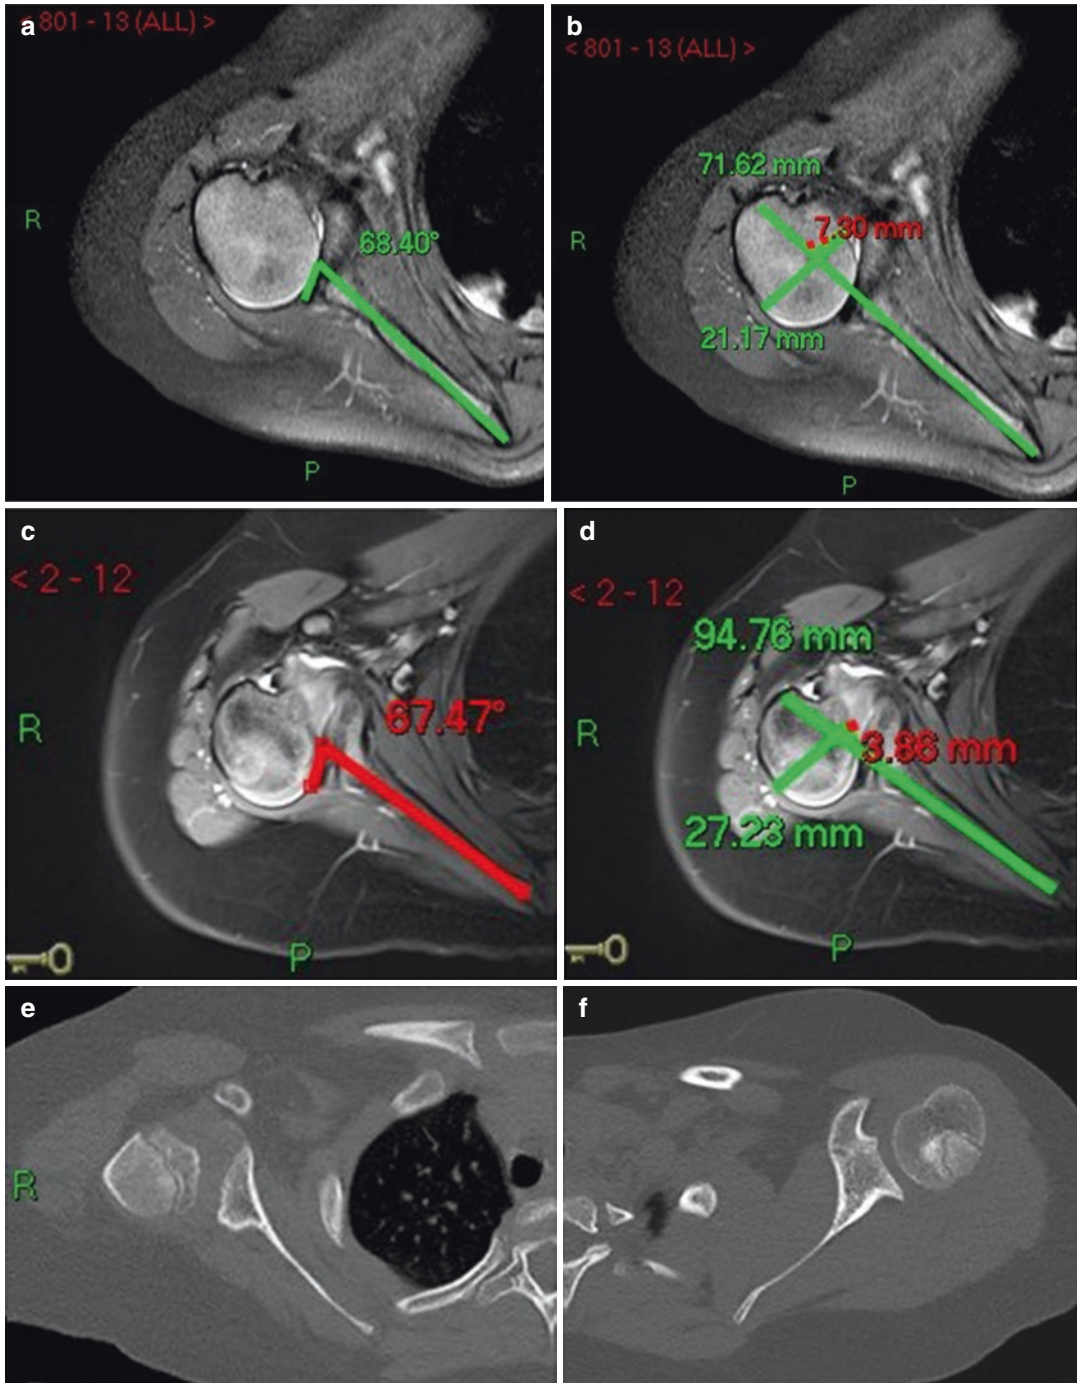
Axial MR images of the right shoulder: at age 16 months, (a) glenoid version = $68-90 = -22^\circ$, (b) percentage of humeral head anterior to the middle of the glenoid fossa = $7/21 \times 100 = 33\%$; the same child at age 6, (c) glenoid version = -23° , (d) percentage
